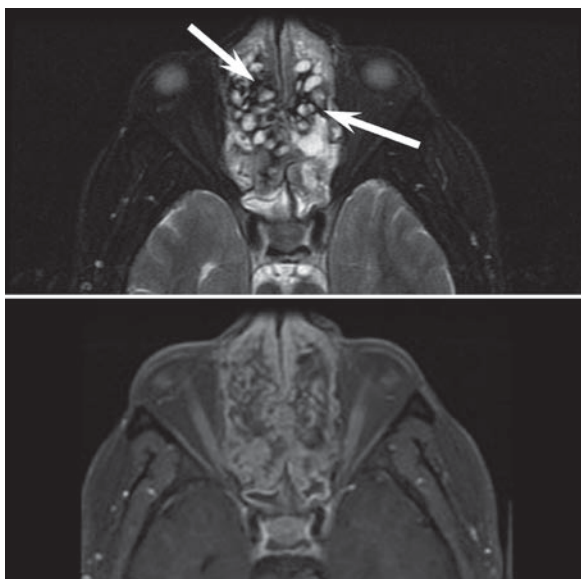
NP complicated by allergic fungal sinusitis (AFS). On the axial T2-weighted image (a), areas of high signal (polyps) alternate with areas of low signal (*arrows*) indicating fungal infection. The corresponding postcontrast T1-weighted image (b) shows the characteristic flowing enhancement pattern of AFS
